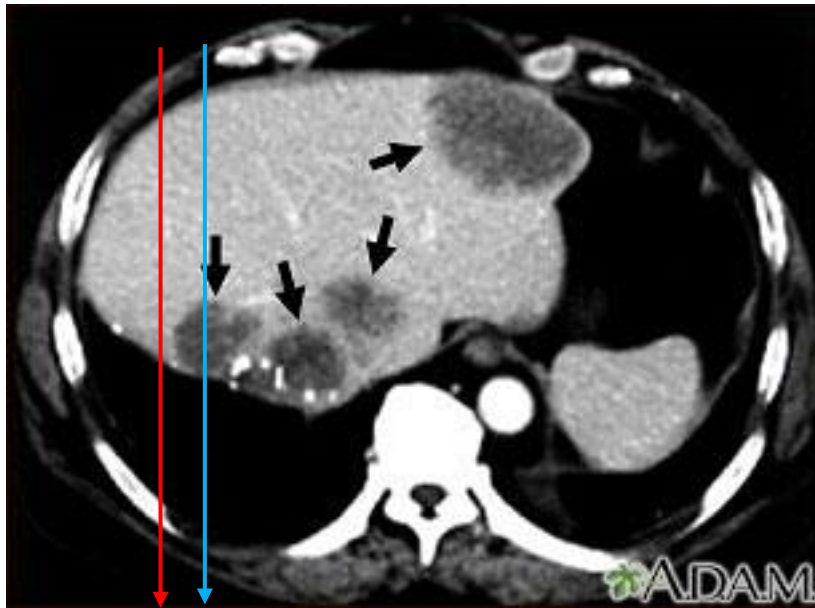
CT scan of the liver showing several large metastases.
